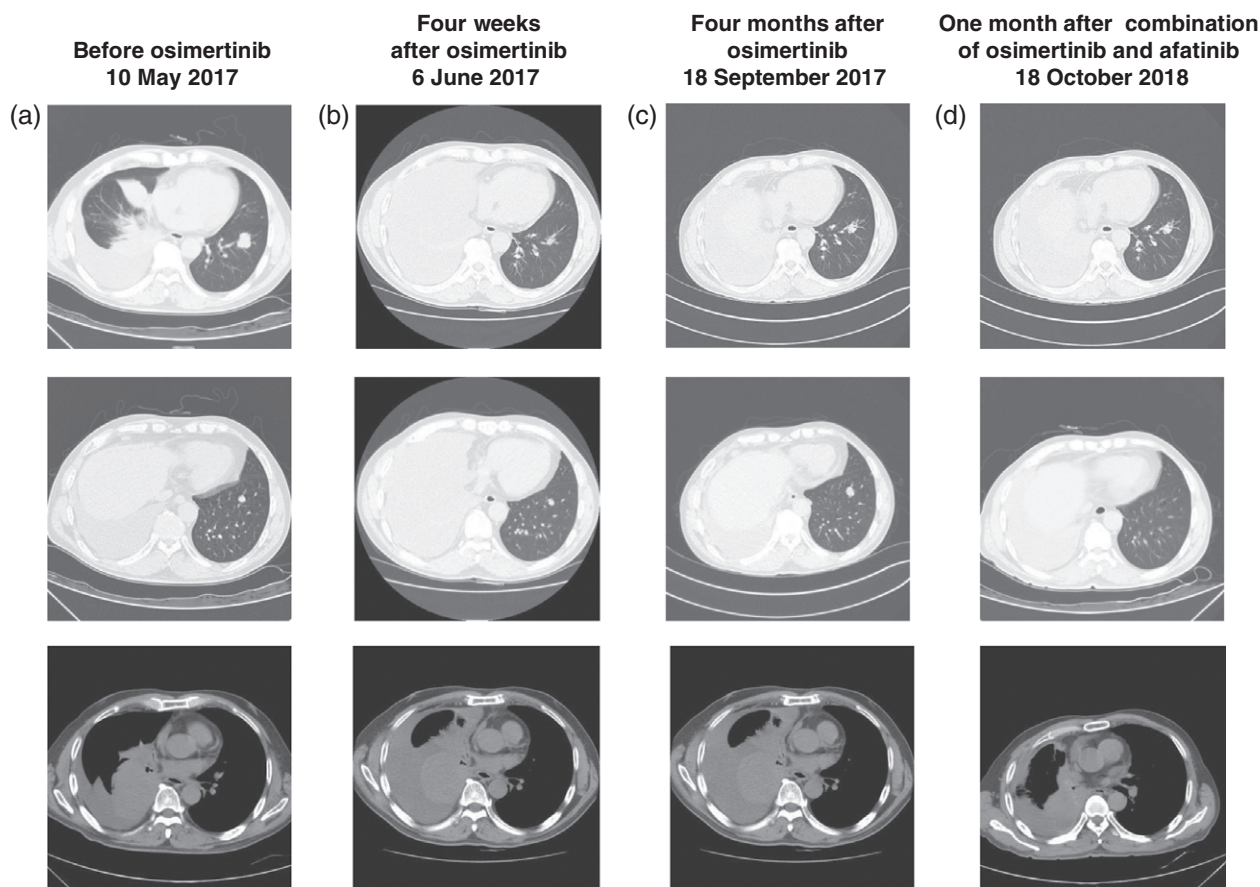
Computed tomography scans taken after (a) icotinib treatment showed a primary mass in the right inferior lobe and multiple metastases; (b) four weeks of osimertinib treatment showed a stable primary tumor, decreased metastases, and increased pleural effusion; (c) four months of osimertinib treatment; and (d) one month of combination osimertinib and afatinib treatment revealed a partial response and significantly improved pleural effusion.
